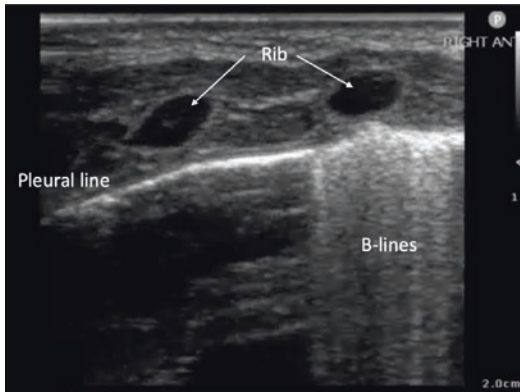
Linear probe 2D ultrasound image for thoracic imaging in an infant identifies minimal rib shadowing because of immature bones with less calcification. Coalescent B-lines are also demonstrated
